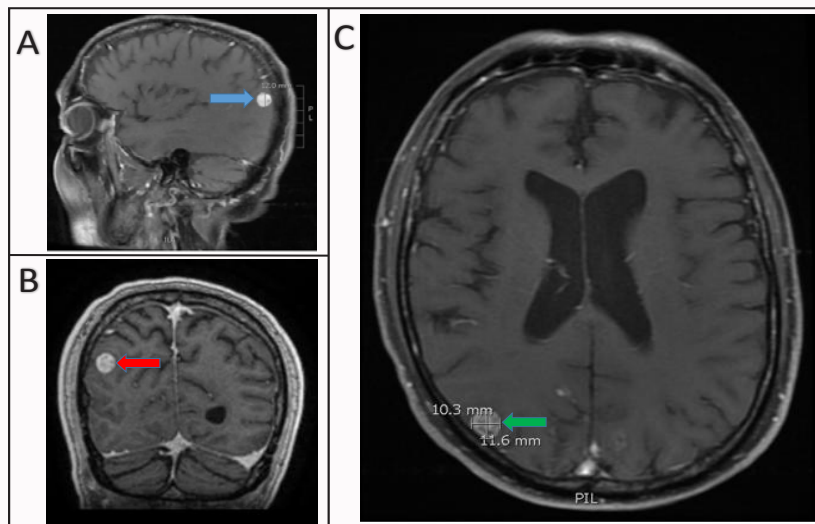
Leptomeningeal metastasis on MRI brain. A) Sagittal view (blue arrow). B) Coronal view (red arrow). C) Transverse view (green arrow).
